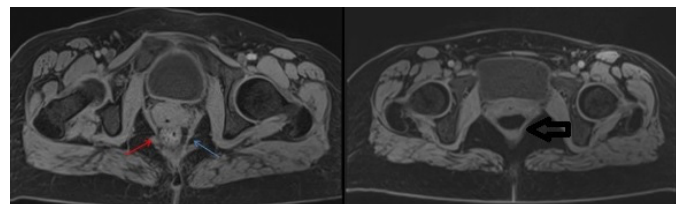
MR images of levator ani muscle, thin arrow shows damaged muscle and thick arrow shows intact muscle
